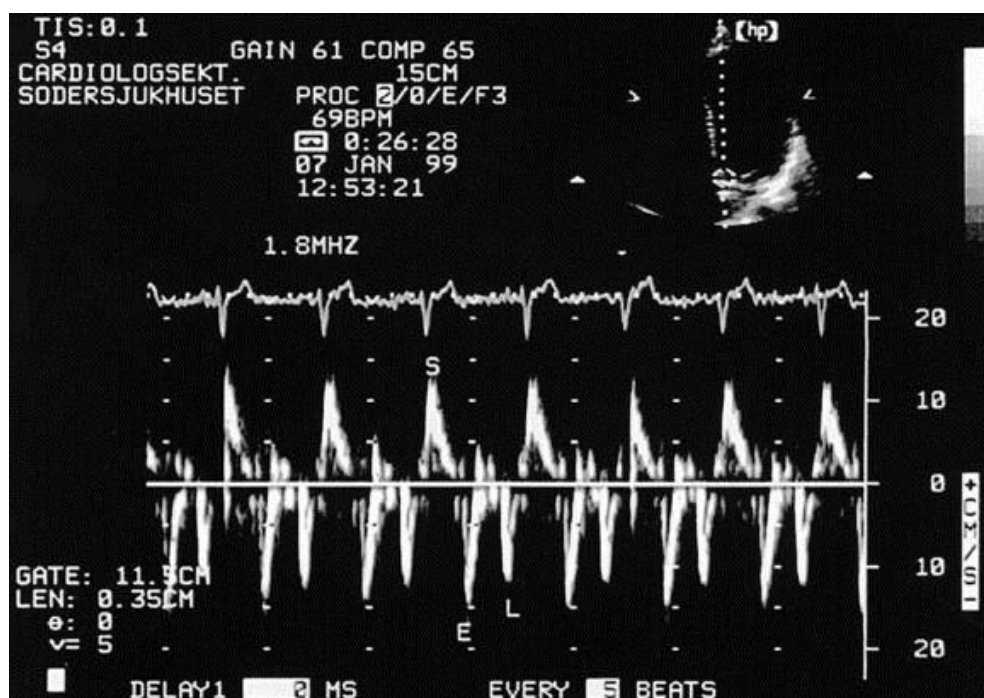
Example of tissue Doppler recording from the septal side of the mitral annulus.
